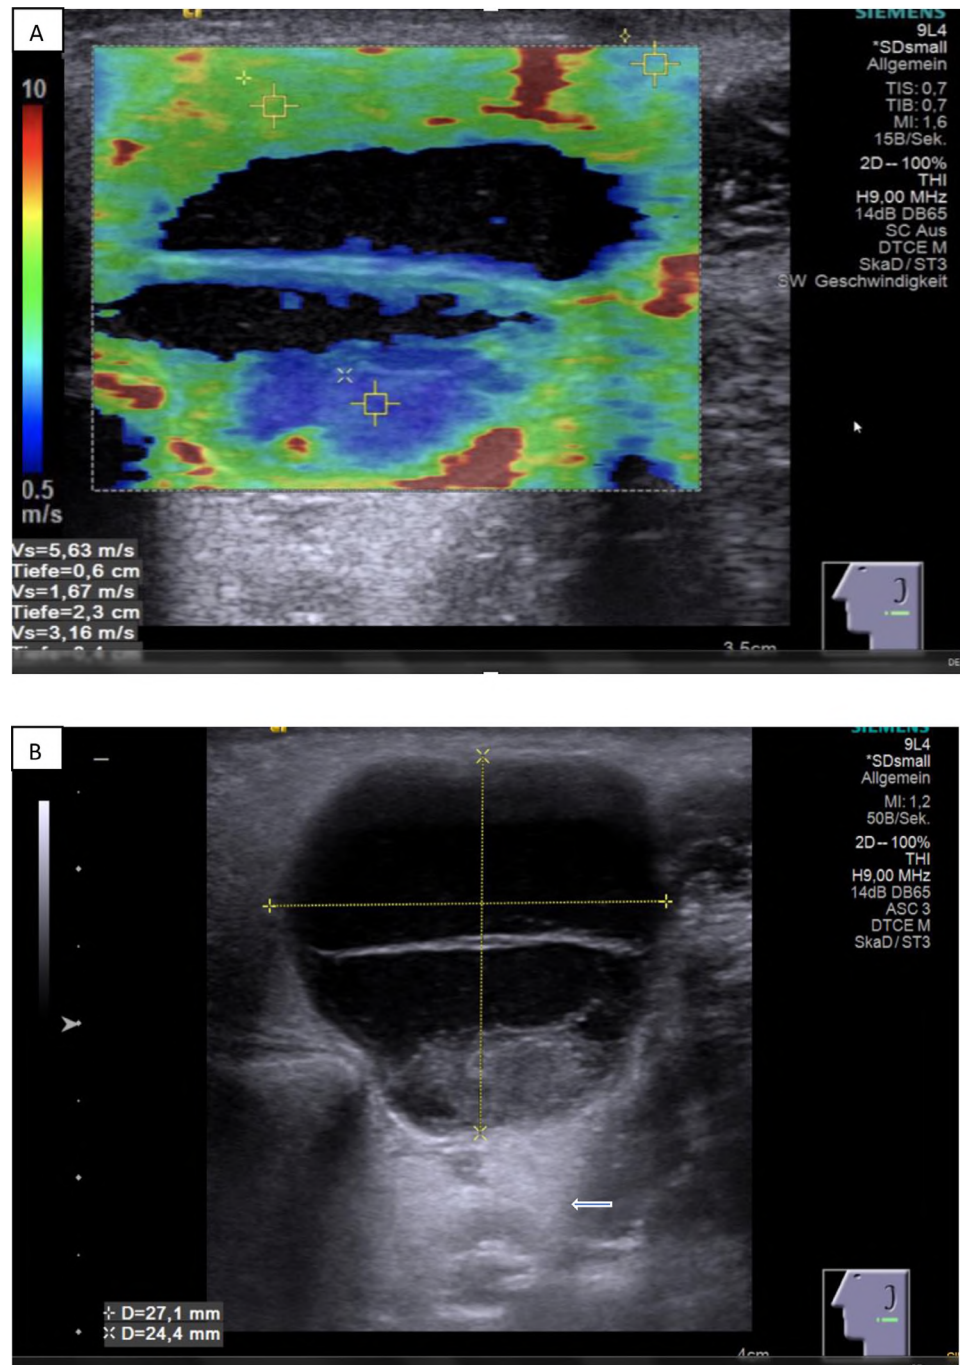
Representative (a) Virtual Touch imaging quantification (VTIQ) and (B) B-mode ultrasound images of a Warthin tumor (WT). (a) Shear wave velocities on the color-coded map generated by VTIQ range from 3.16 to 5.63 m/s. Shear wave velocity cannot be measured in cystic areas by VTIQ, and therefore, cystic areas are not color-coded. Shear wave velocity measurements were obtained in surrounding tissue within the WT for analysis. Regions of interest where VTIQ measurements were performed are denoted by *small yellow squares*. (b) WT on B-mode ultrasound with distal enhancement (*arrow*).
